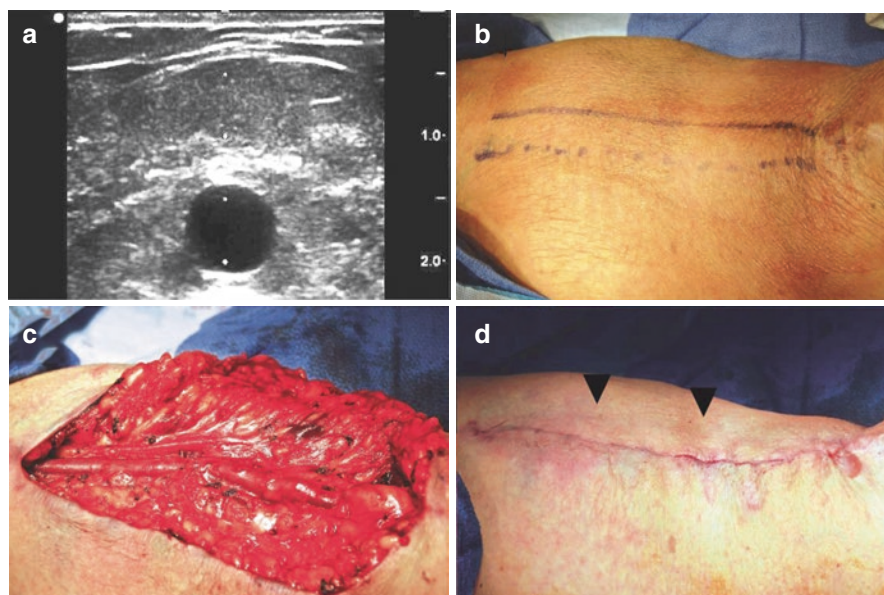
Lipectomy for superficialization of cephalic fistula vein. (a) A preoperative ultrasound image shows fistula vein about 13 mm deep. (b) An incision is planned (*dotted markings*) medial to the fistula vein (*solid marking*). (c) The subcutaneous adipose tissue over the fistula vein is resected carefully. (d) The skin is closed. The fistula vein is now just underneath the skin (*arrowheads*). A Jackson-Pratt drain may be used to prevent fluid collection over the fistula vein
